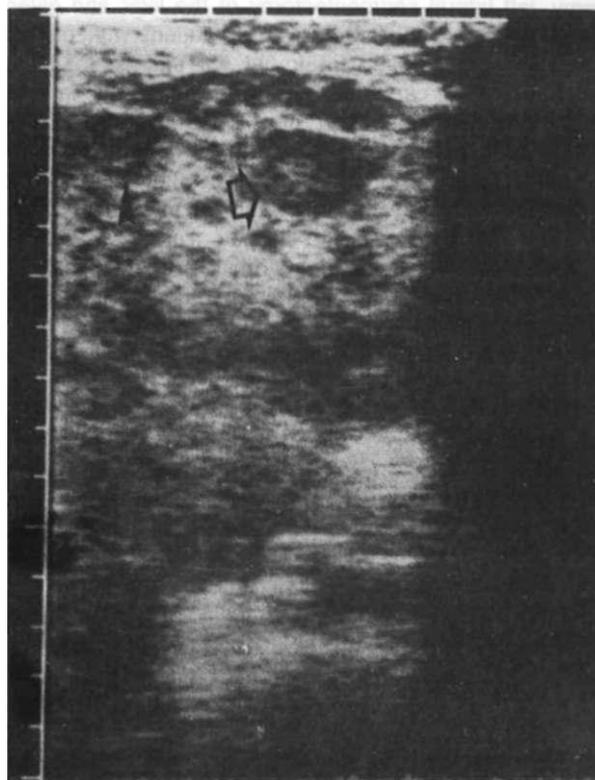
Ultrasonography shows multiple small hypoechoic lesions (arrows).
